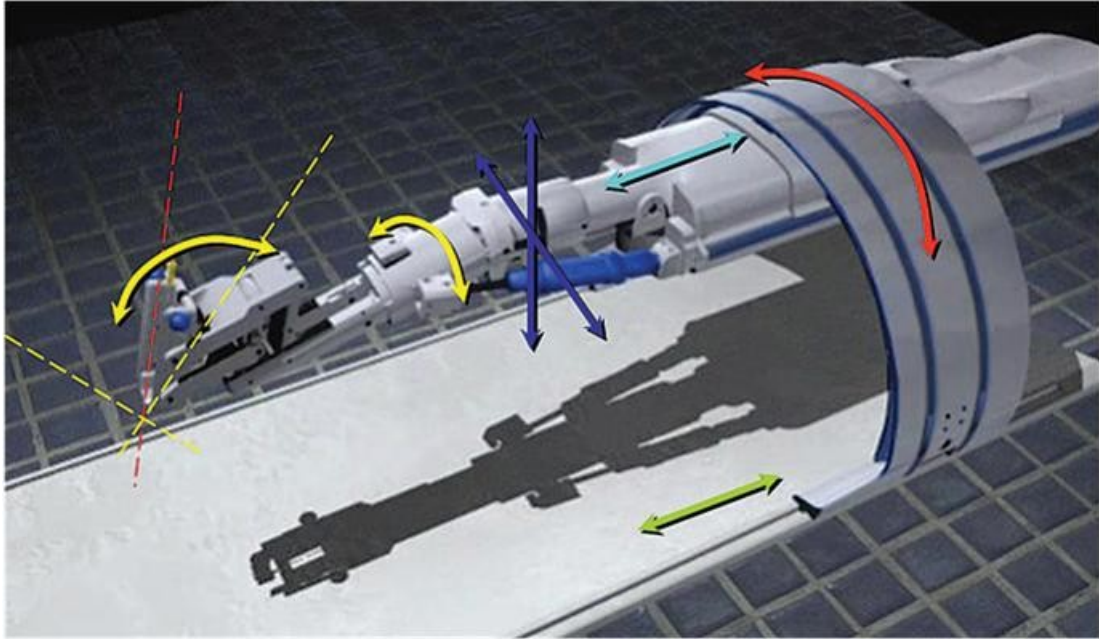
Innomotion MRI-guided needle insertion arm with pneumatically actuated DOF shown [Melzer, 2008].
